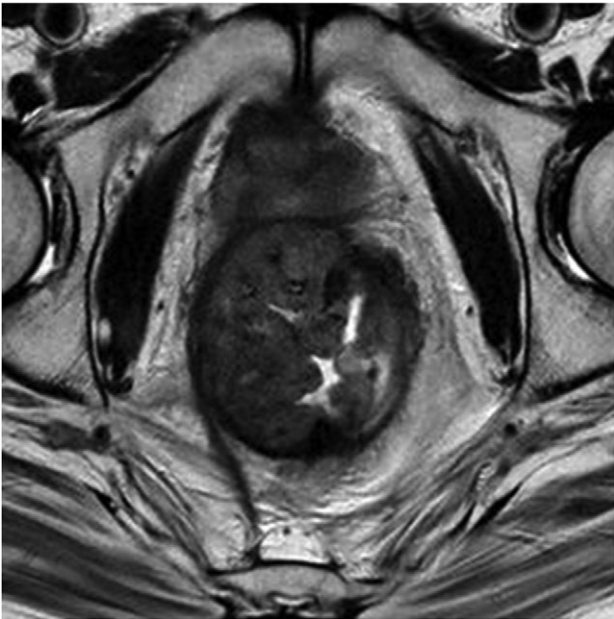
MRI pelvis. T2 axial image through pelvis demonstrating limited response to chemoradiotherapy with tumoral margins still predicted positive.
